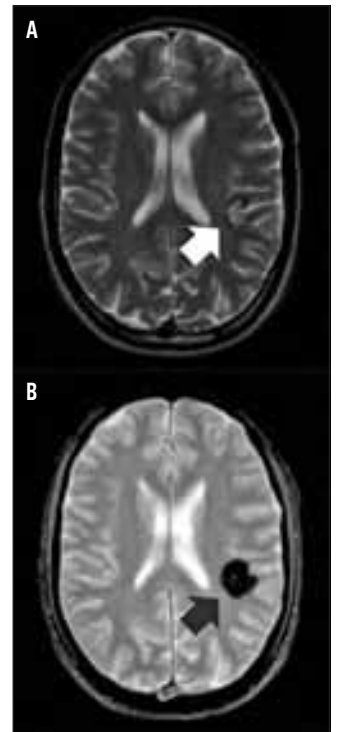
MRI of Cavernous Malformation
